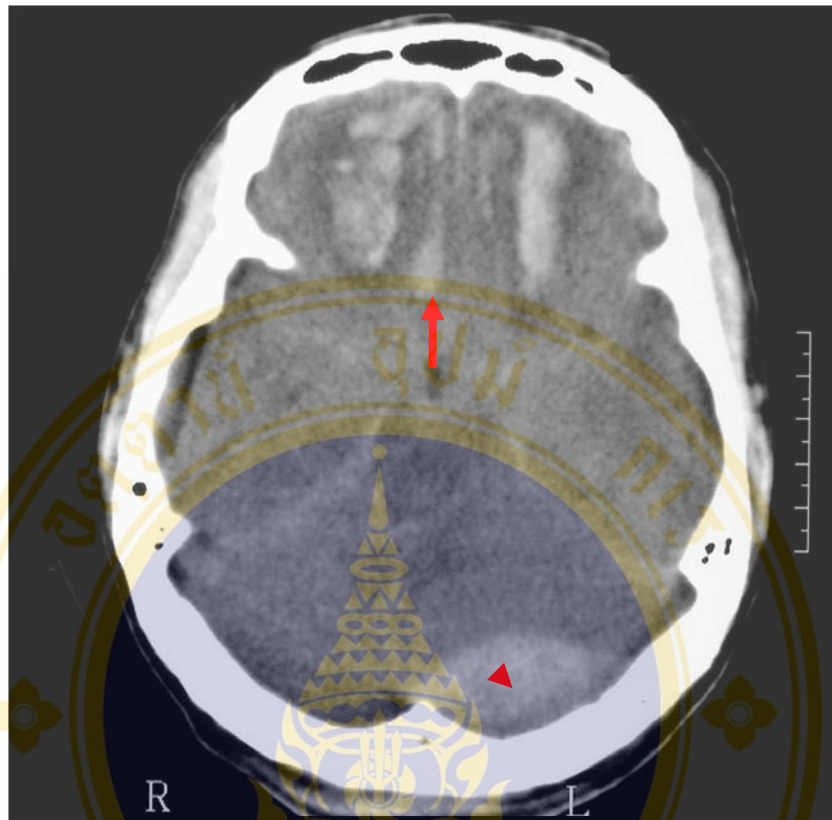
Cranial CT scans of head injury patient showed areas of hemorrhage in bifrontal lobes caused by gliding of brain tissue over cranial bone (arrow). Another hyperdensity of lentiform hematoma as epidural hematoma is demonstrated in left occipital region (arrow head)
